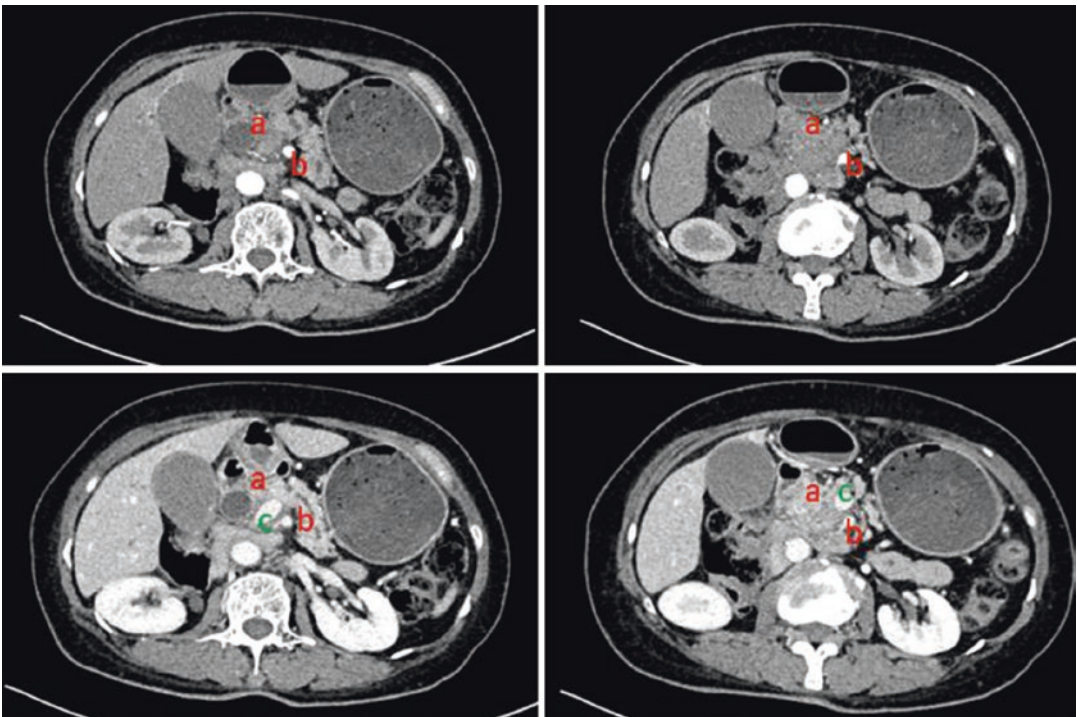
CT showed pancreas head carcinoma. (a) Mass. (b) SMA. (c) SMV
